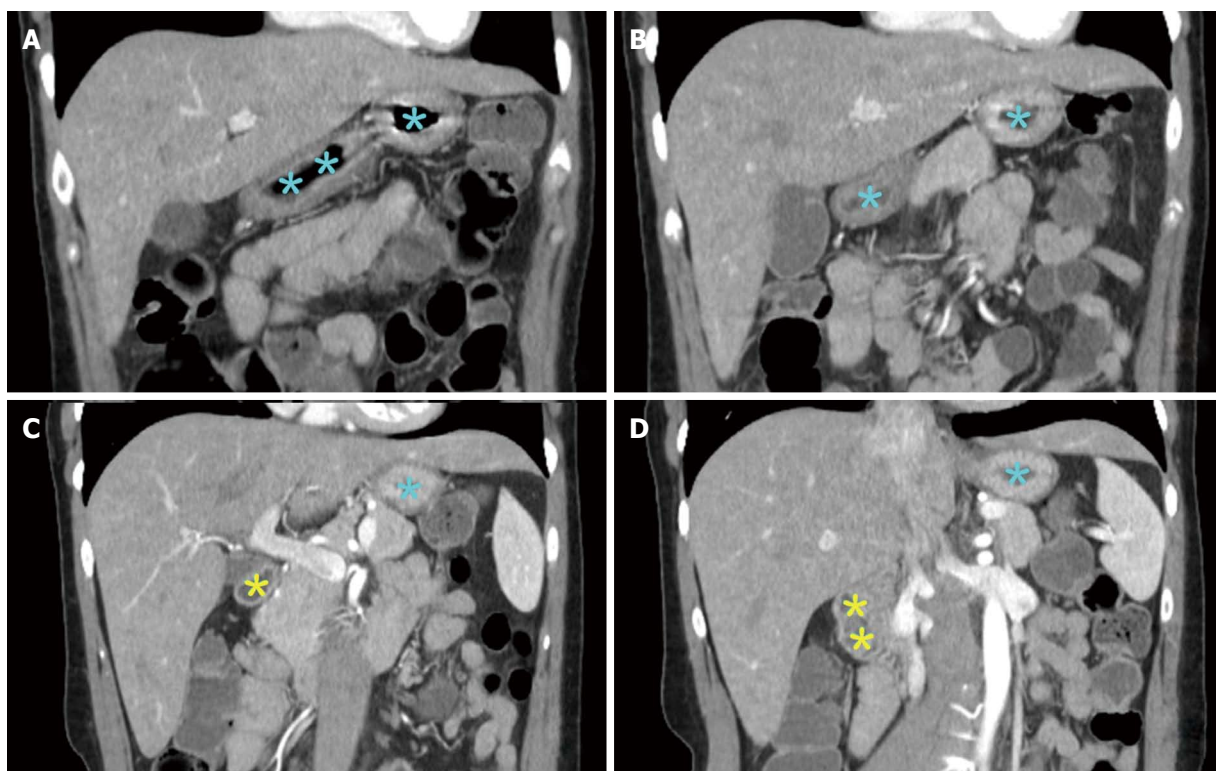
Selected computerized tomography scan images showing the liver and its surrounding stomach and duodenum. Both the left lobe and caudate lobe lie in close proximity to stomach (blue colored asterisk indicated gastric lumen) and duodenum (yellow colored asterisk indicated bulb and duodenal lumen), hence providing an easy access during endoscopic ultrasonography (EUS). The caudate lobe and gastrohepatic space can be accessed by EUS while are anatomically difficult to approached by trans-abdominal ultrasound. EUS is limited in its ability to access the portion of the right lobe adjacent to the dome of the diaphragm along with its lateral and inferior portions.
